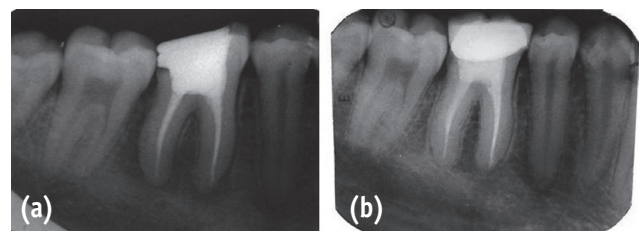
(a) Post-obturation radiograph; (b) Two-year follow up radiograph.
